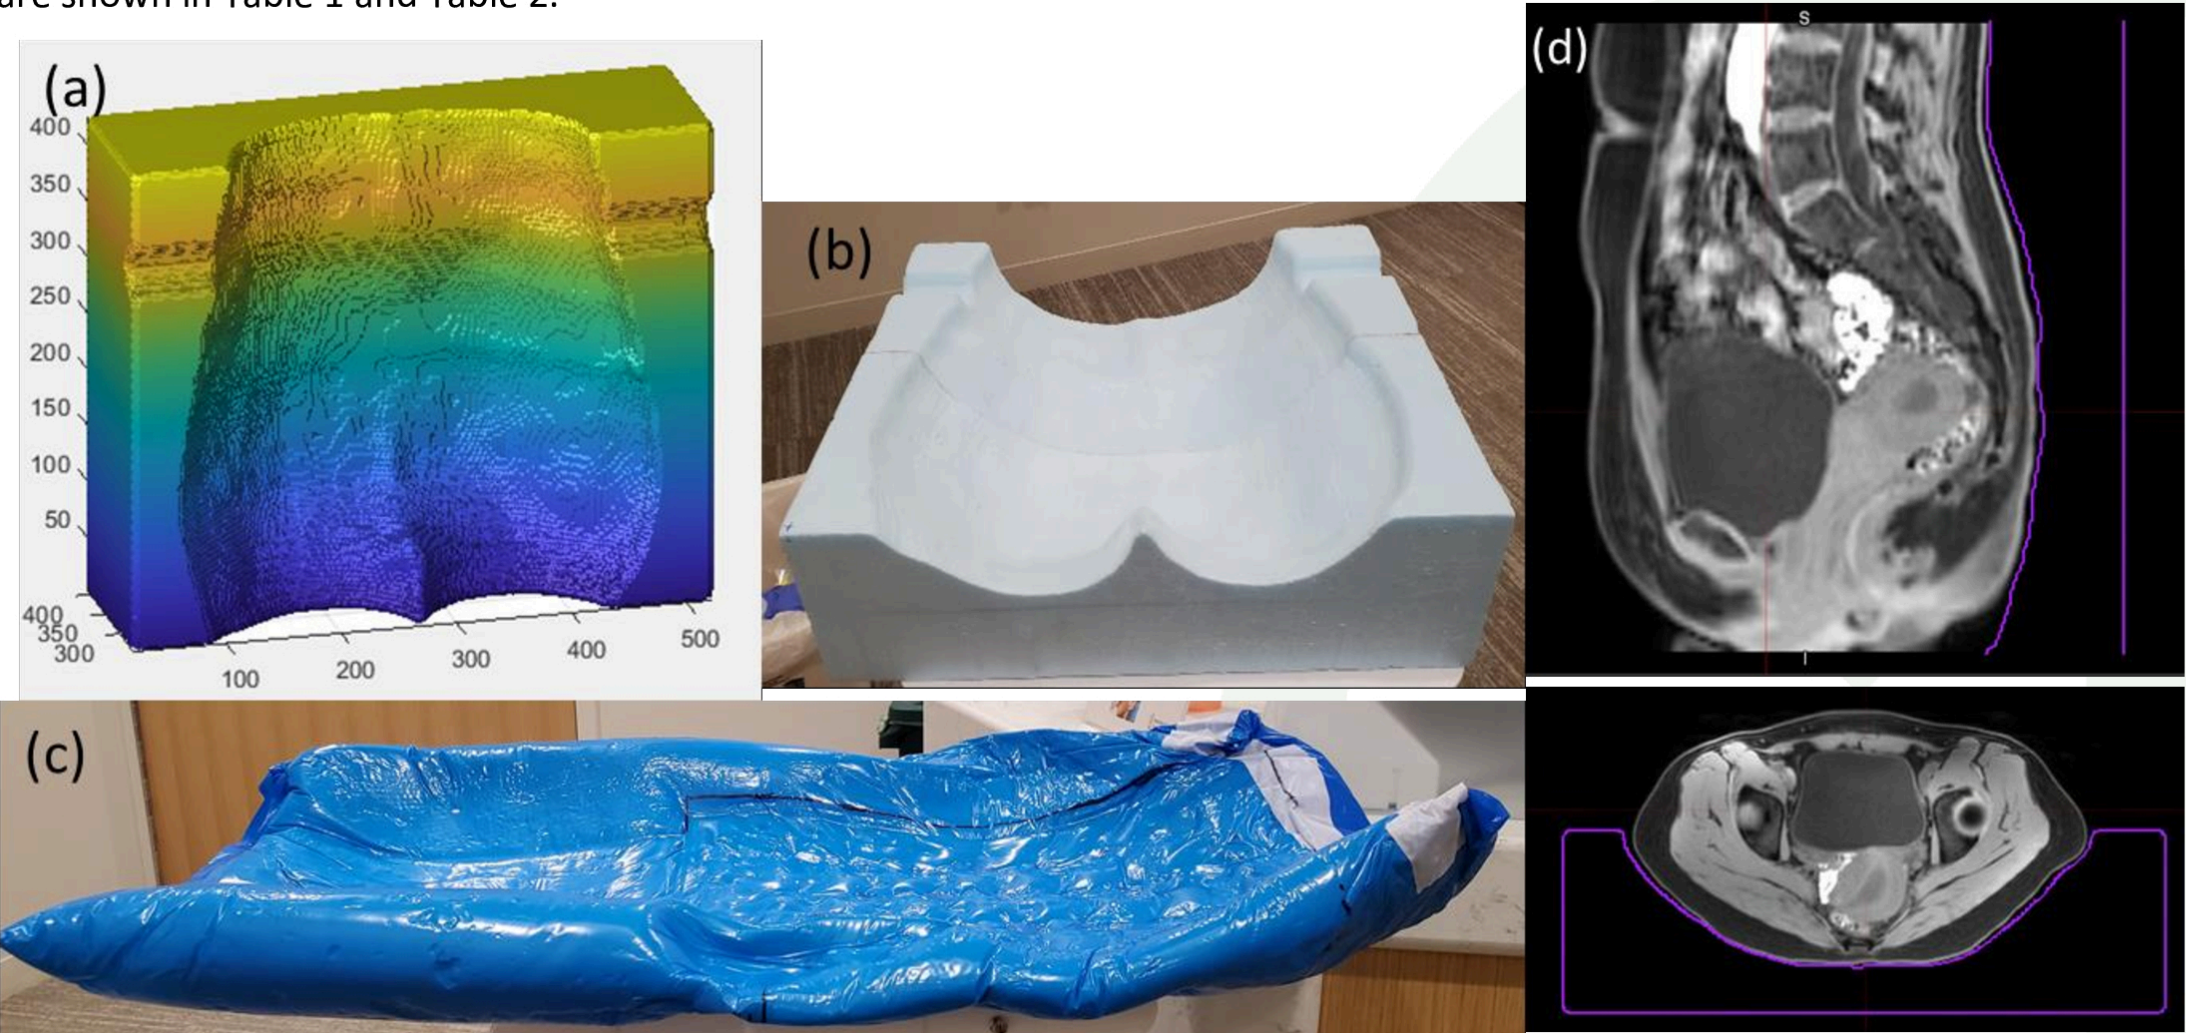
(a) stl surface for custom image-based immobilization device fabrication. (b) custom image-based immobilization device (c) volunteer alpha cradle (d) immobilization device contour with MR image
